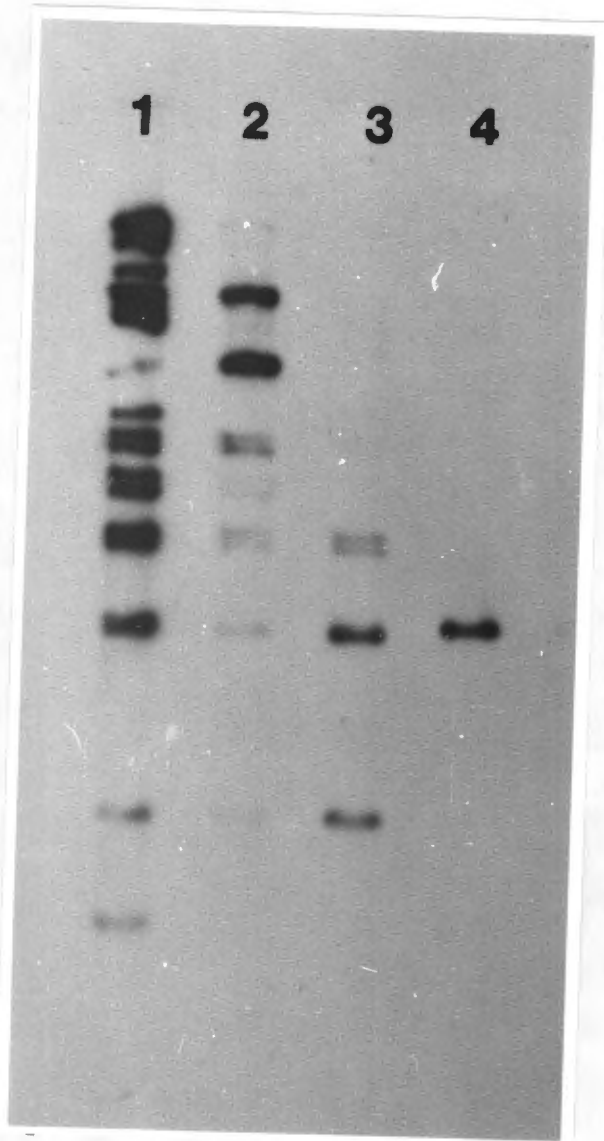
Autoradiograph of Sq 249 Pst I blot (deca-probe apparatus) probed with ^{32}P -labelled Mp Benin Pst I fragments. Lanes 1 - 4. 1: Mp Benin whole genome; 2: Pst I H; 3: Pst I K; 4: Pst I N. X-ray film exposed overnight.
